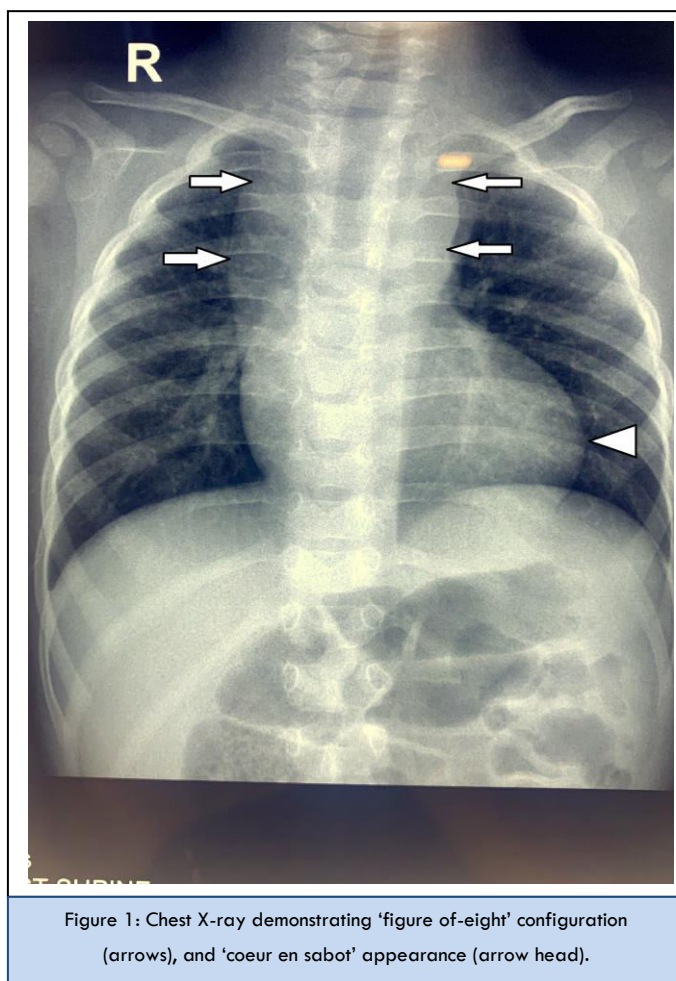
Chest X-ray demonstrating 'figure-of-eight' configuration (arrows), and 'coeur en sabot' appearance (arrow head).
